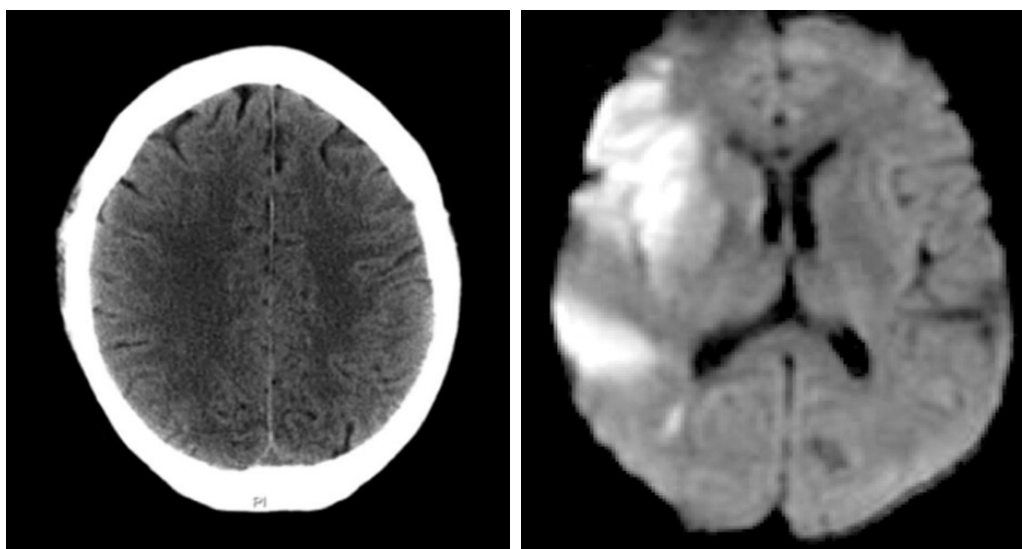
Normal CT scan and Magnetic Resonance (MRI) showing right side acute ischemic stroke.
